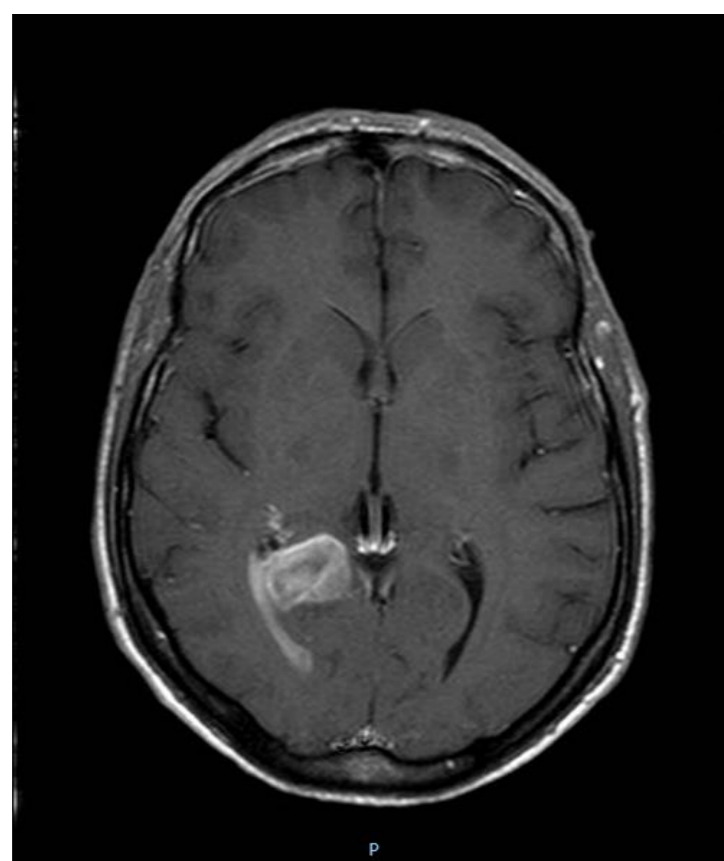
MRI T1 GD, axial scan
